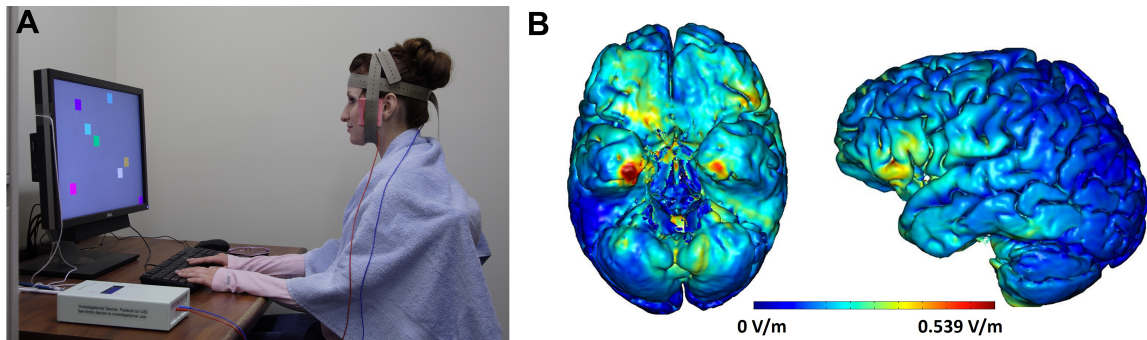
A) The standard tDCS set up while the participant receives stimulation. B) Current modeling of F3 anodal stimulation with the cathodal electrode on the right cheek. Models of current flow are important for predicting the path of least resistance between the two electrodes. Given the relative unknown of tDCS mechanisms, current modeling provides some clues as to which regions of cortex may be affected by tDCS as well as how diffuse the stimulation is underneath the electrodes. Red indicates areas affected by tDCS and current flow path. This analysis confirmed that tDCS to the PFC supplied current to PFC regions, but current also reached orbitofrontal and ventral temporal regions. High-resolution individualized models were derived from MRI data (1mm T2-weighted scan). The MRI scans were segmented into several tissues: skin, fat, bone, CSF, gray matter, white matter, air, and deep brain structures. Segmentation was carried out using Simpleware ScanIP (Simpleware Ltd., Exeter, UK). The electrodes were created in SolidWorks (Dassault Systèmes Corp., Waltham, MA) and oriented on the head using ScanCAD (Simpleware Ltd., Exeter, UK). The head, now with the electrodes placed, was imported back to ScanIP to generate a volumetric mesh and current flow was plotted on to the cortex (Bikson, Rahman, Datta, Fregni, & Merabet, 2012).
